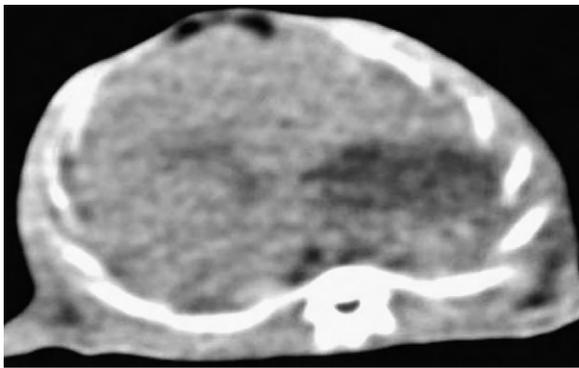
Precontrast CT scan of the upper abdomen performed to choose an appropriate slice including the aorta, portal vein and liver parenchyma.
